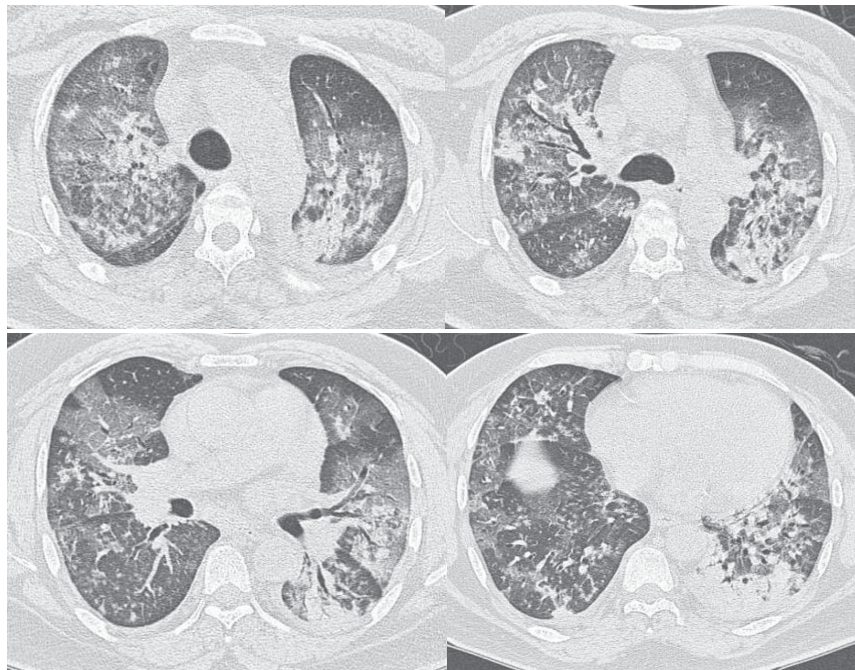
The high resolution computerized tomography (HRCT) of the chest shows asymmetrical patchy consolidation. The change predominates over both upper lobes and the left lower lobe. There are diffuse ground-glass opacities at both lungs without pleural effusion.
